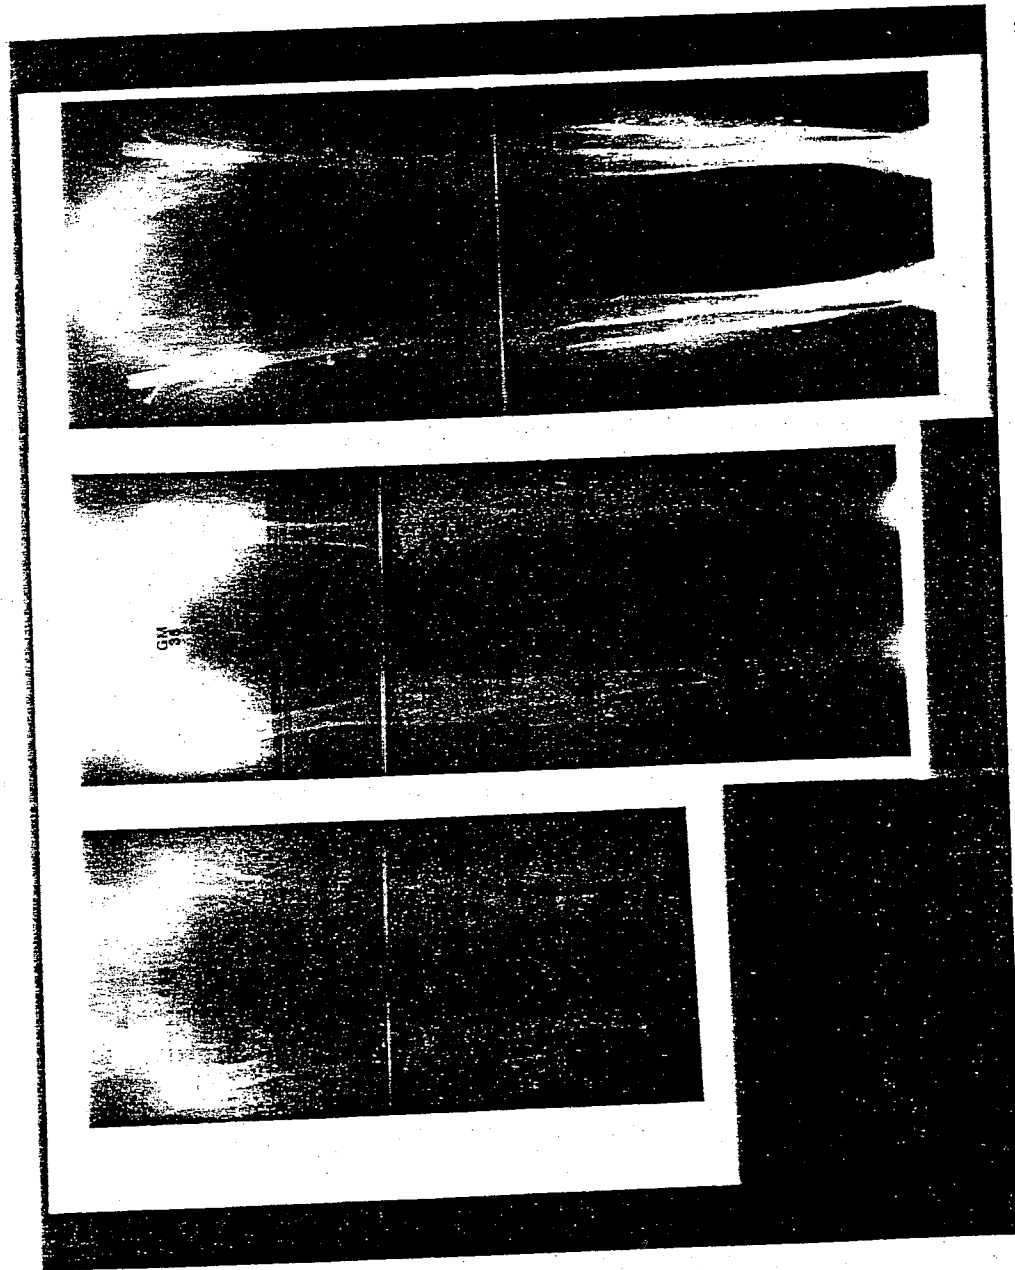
Radiographs of staged lengthening in an achondroplastic dwarf. First panel: initial standing leg radiograph at age 12. Second panel: same view after double level tibial lengthening of 16 cm. Third panel: final view after 10 cm bilateral femoral lengthening over intramedullary nails. Total lengthening = 26 cm.
